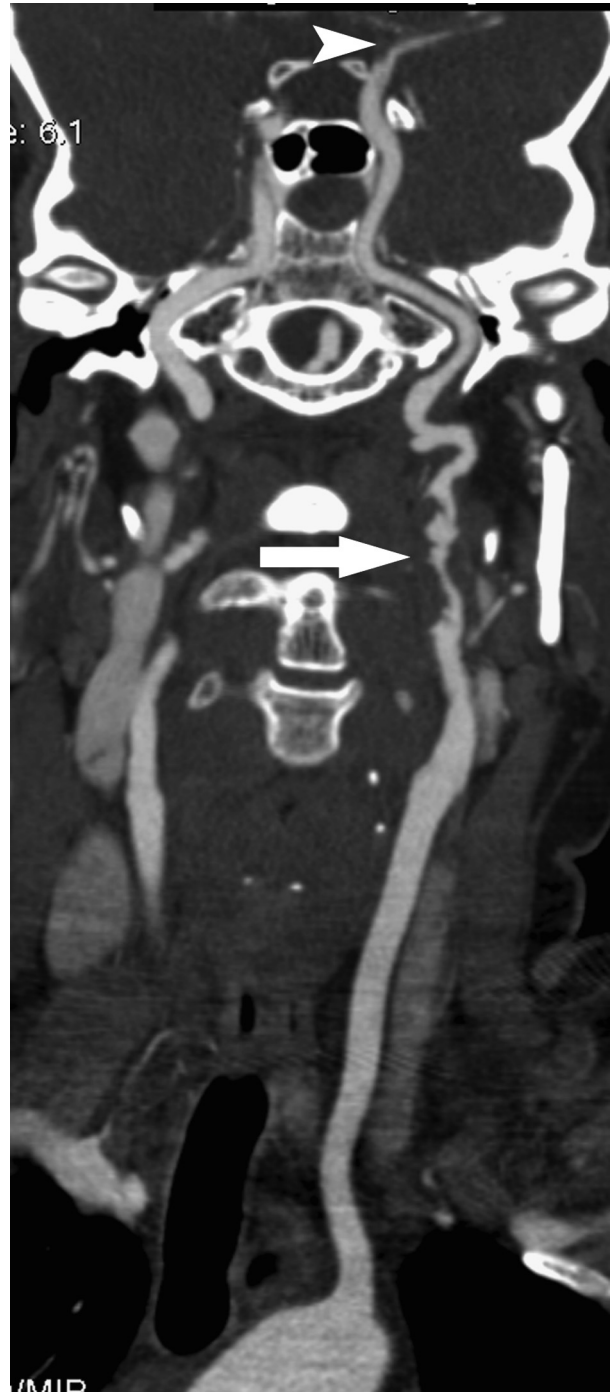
Axial image from computed tomography angiogram demonstrates dissection and subtotal occlusion of the left internal carotid artery (white arrow) just proximal to the foramen lacerum.
